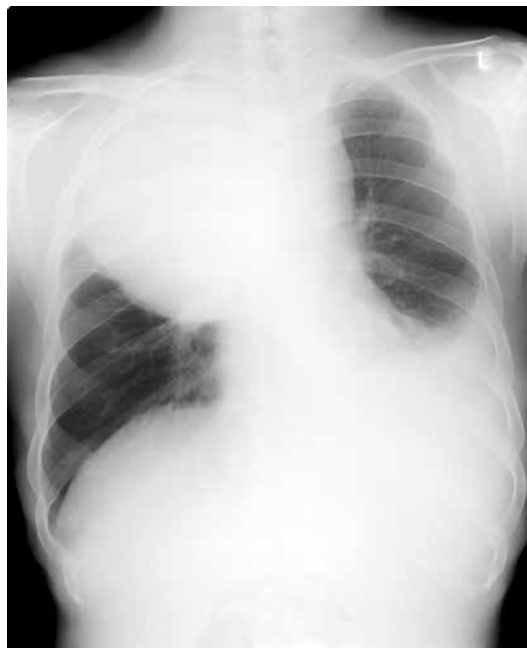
Chest X-ray showing huge mediastinal mass in the right upper zone of the lung
